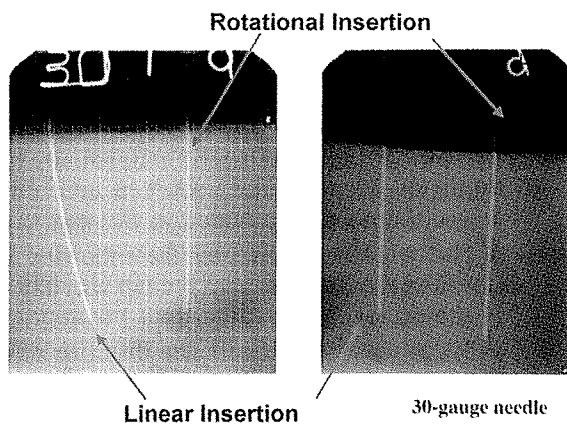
Insertion of a 30-gauge needle with 2 different techniques: linear insertion and bidirectional rotation insertion. Radiographs represent needle insertion in 2 planes of space fixed 90 degrees from each other.
